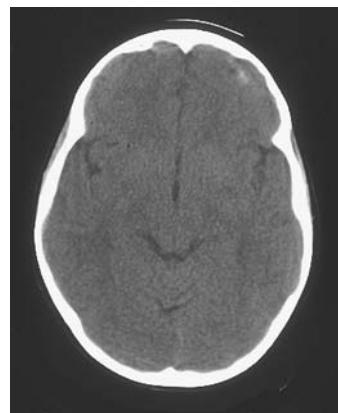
Post-operative head CT scan (parenchymal window) demonstrating evacuation of the left frontal epidural hematoma
